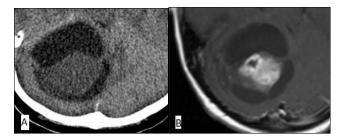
Pilocytic astrocytoma A. CT image showing cystic density tumour with a mural nodule (Solid isodense area) B. MRI showing contrast enhancement in the mural nodule with surrounding non-enhancing cystic area
